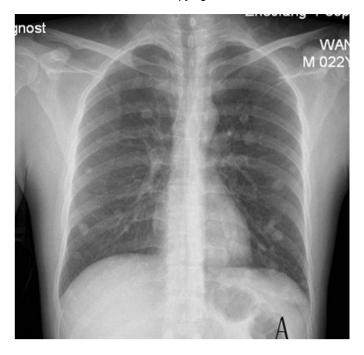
Chest radiography evidence of lung metastasis
